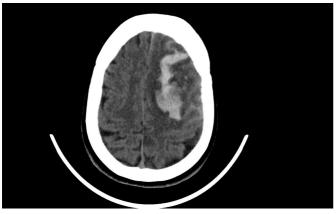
Computed tomography image taken at the time of presentation showing intracranial hematoma and a shift to the right
